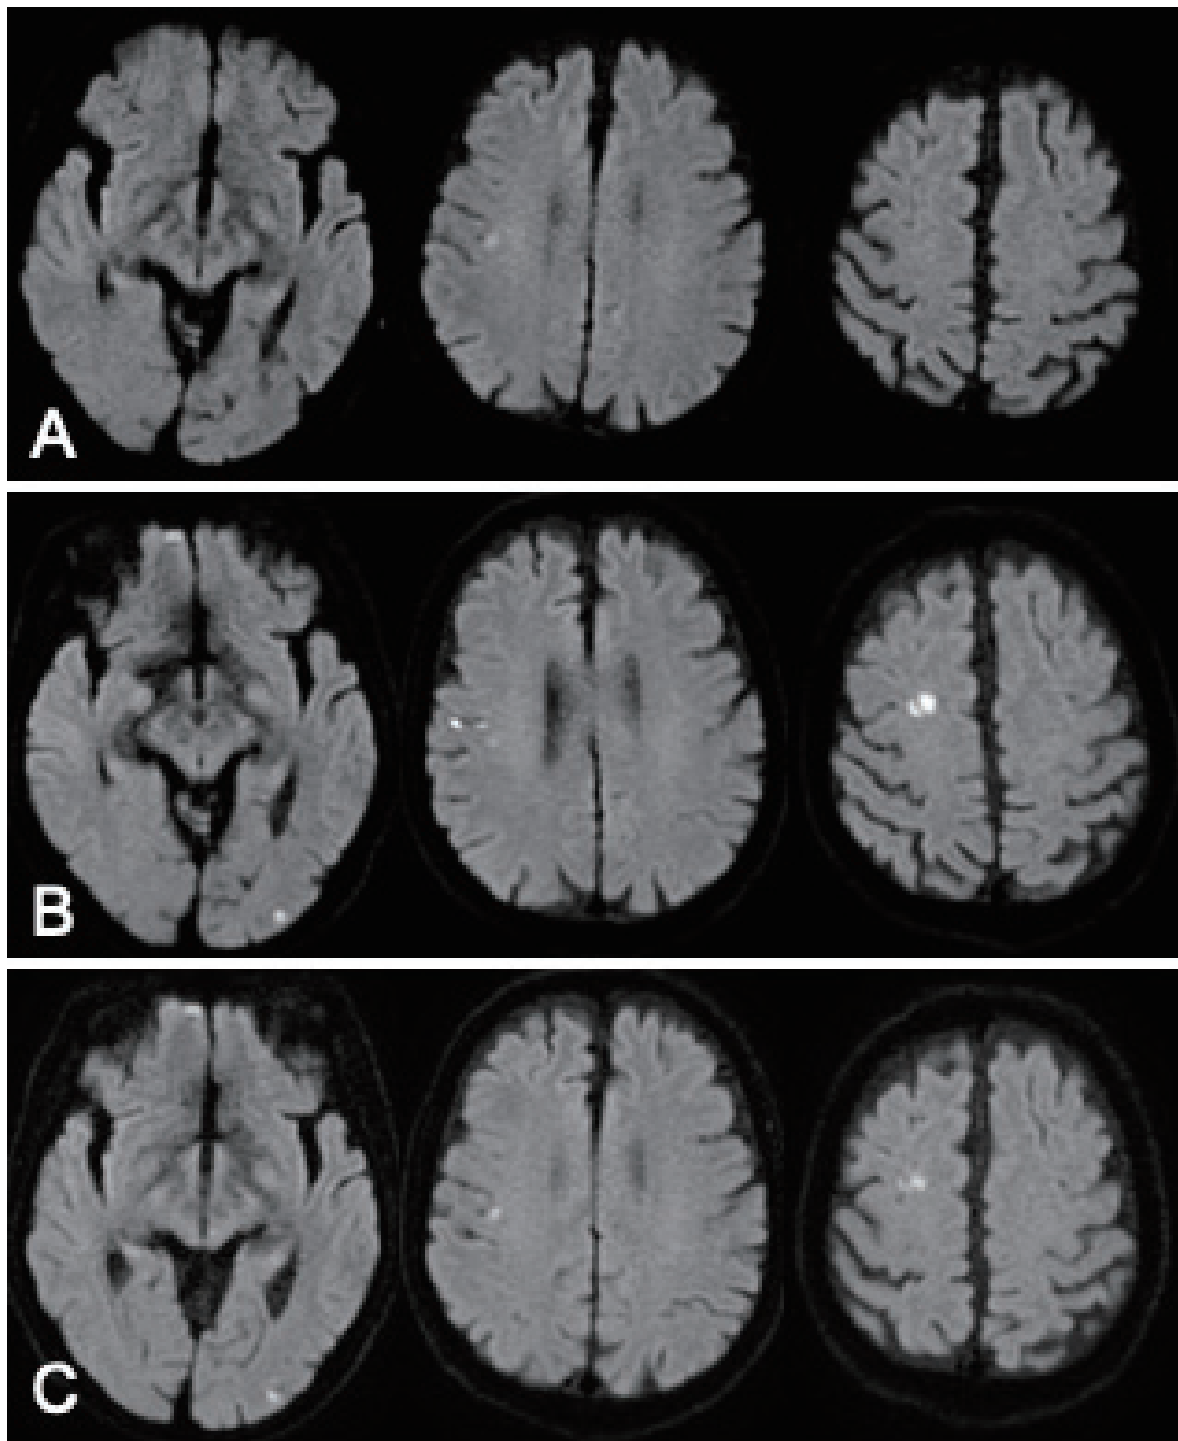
Diffusion-weighted brain MRI scans (axial images).
